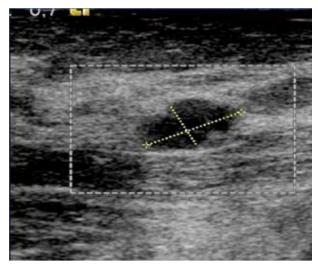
Ultrasound examination showed a heterogeneous wellcircumscribed cystic lesion with a solid nodule.
